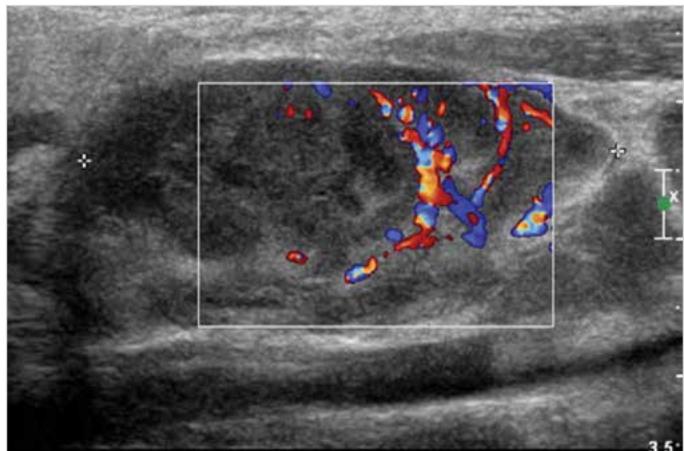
Doppler ultrasound – lymph node package with signs of decay.
